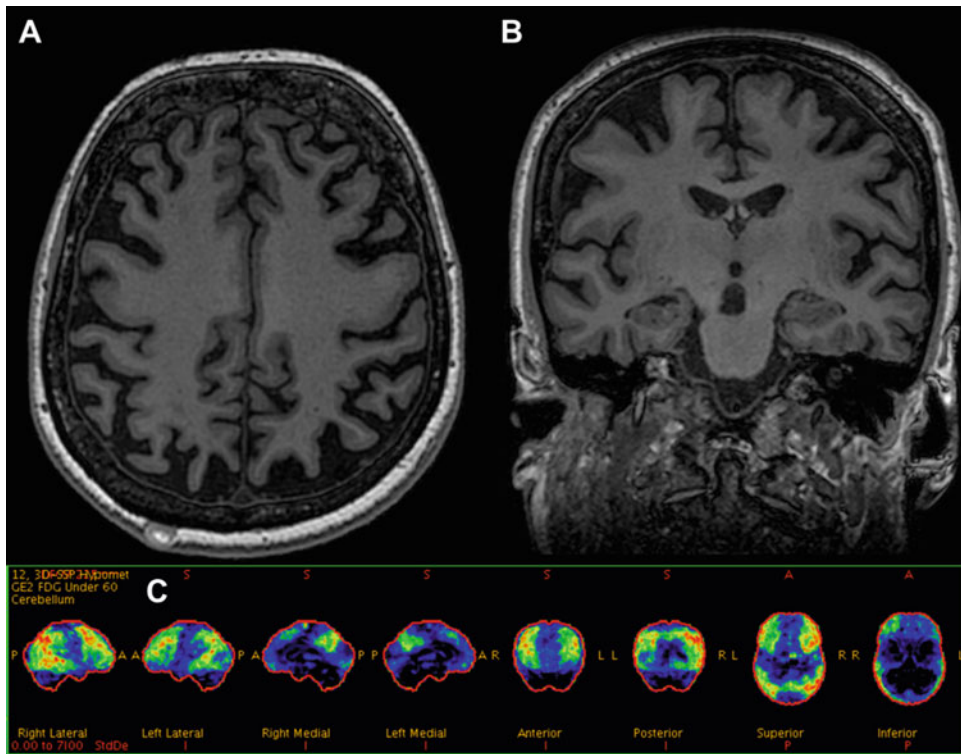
52-year-old woman with progressive memory loss and frontal symptoms. Axial T1w MRI (a) demonstrates fronto-parietal atrophy, without significant hippocampal atrophy (MTA 0, b). Parametric analysis of FDG
